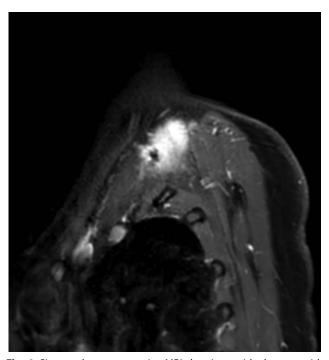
Six months postoperative MRI showing residual tumor with regrowth.
